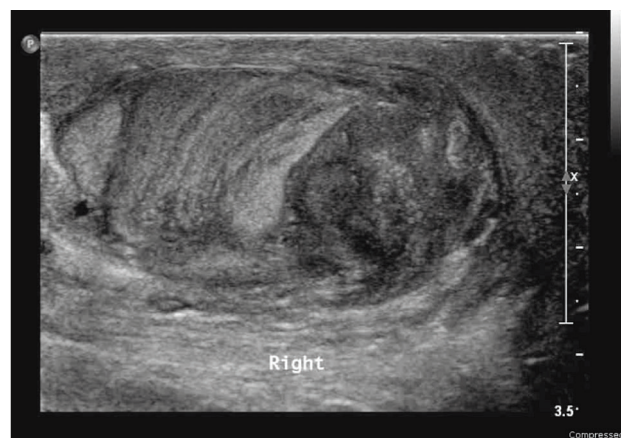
Gray-scale sonography of patient with right epididymo-orchitis shows heterogeneous echogenicity of right testis.
